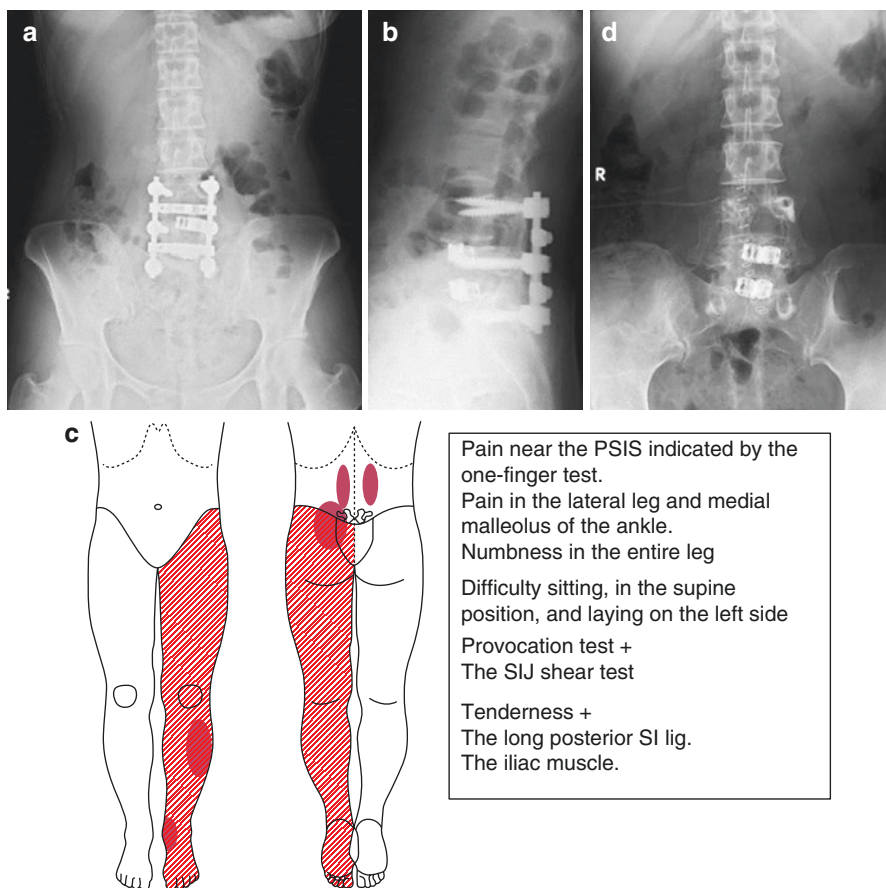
(a) AP view of lumbar spines on X-ray. (b) Lateral view of lumbar spines on X-ray. (c) Pain area and physical findings; highlighted area indicates area of numbness. (d) AP view of lumbar spines on X-ray (after removing internal instruments). With permission from [1]
